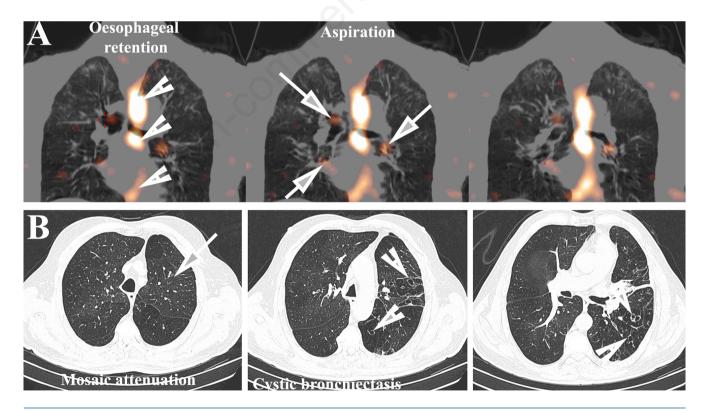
A) Coronal images from a low-dose SPECT/CT study of the lungs which shows significant retention of refluxate in the oesophagus (arrowheads) and refluxate located in the main bronchi (arrows). B) High-resolution transaxial CT images of the chest showing a combination of mosaic attenuation (arrows) and cystic bronchiectasis (arrowheads).
